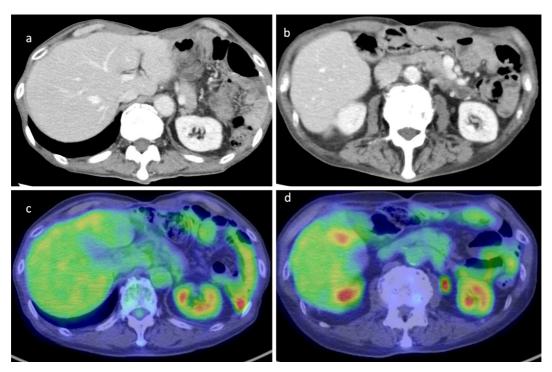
Images after stopping nivolumab. Contrast-enhanced CT images 4 months after discontinuation of nivolumab (a, b) and 18F fluoro-2-deoxyglucose positron emission tomography images 16 months after discontinuation of nivolumab (c, d). CT: computed tomography
